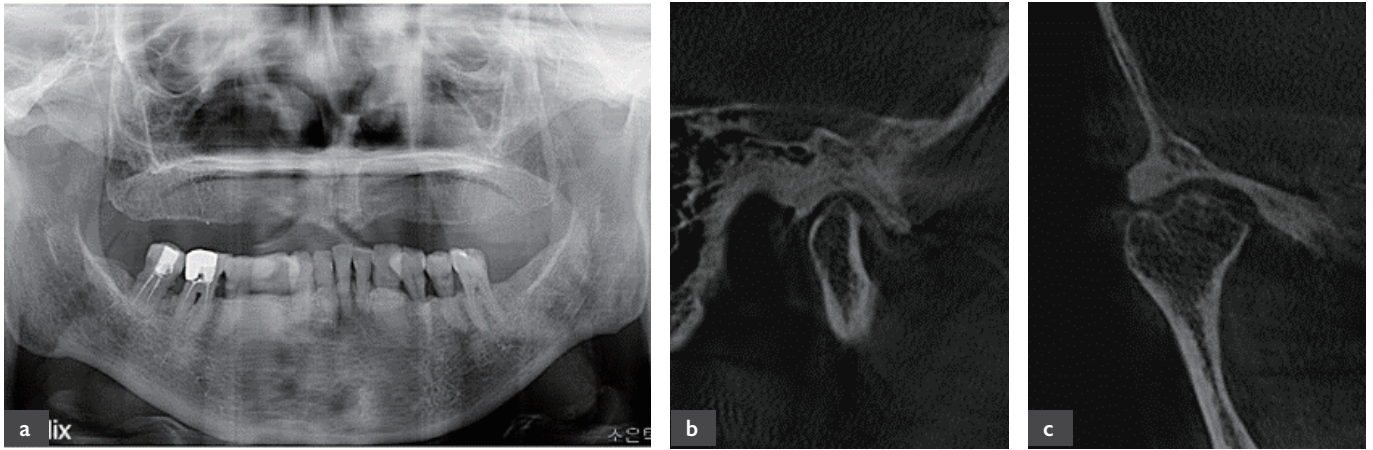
Follow-up CBCT Series of Left Condyle
